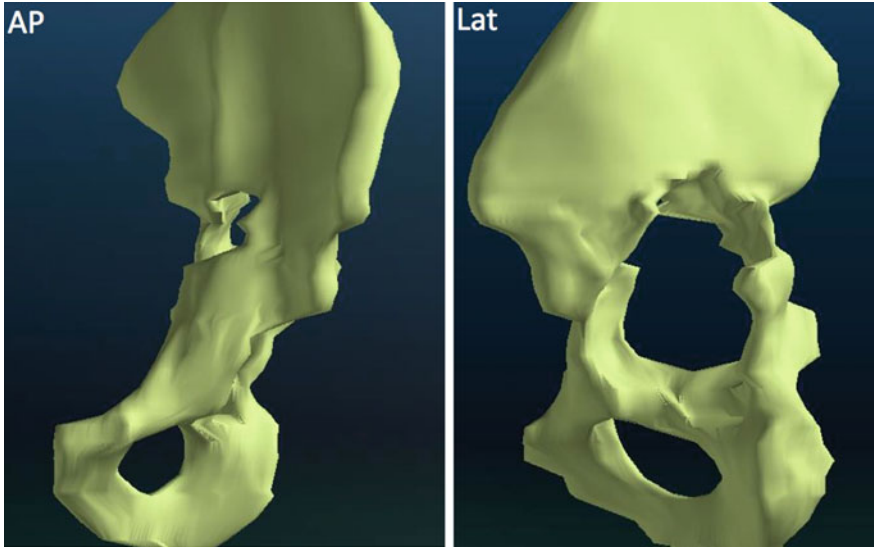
Preoperative 3D reconstruction based on patient CT data. Medial breakthrough and cranial defect, unstable dorsal and ventral pillars. Classified as Paprosky Type IIIb
